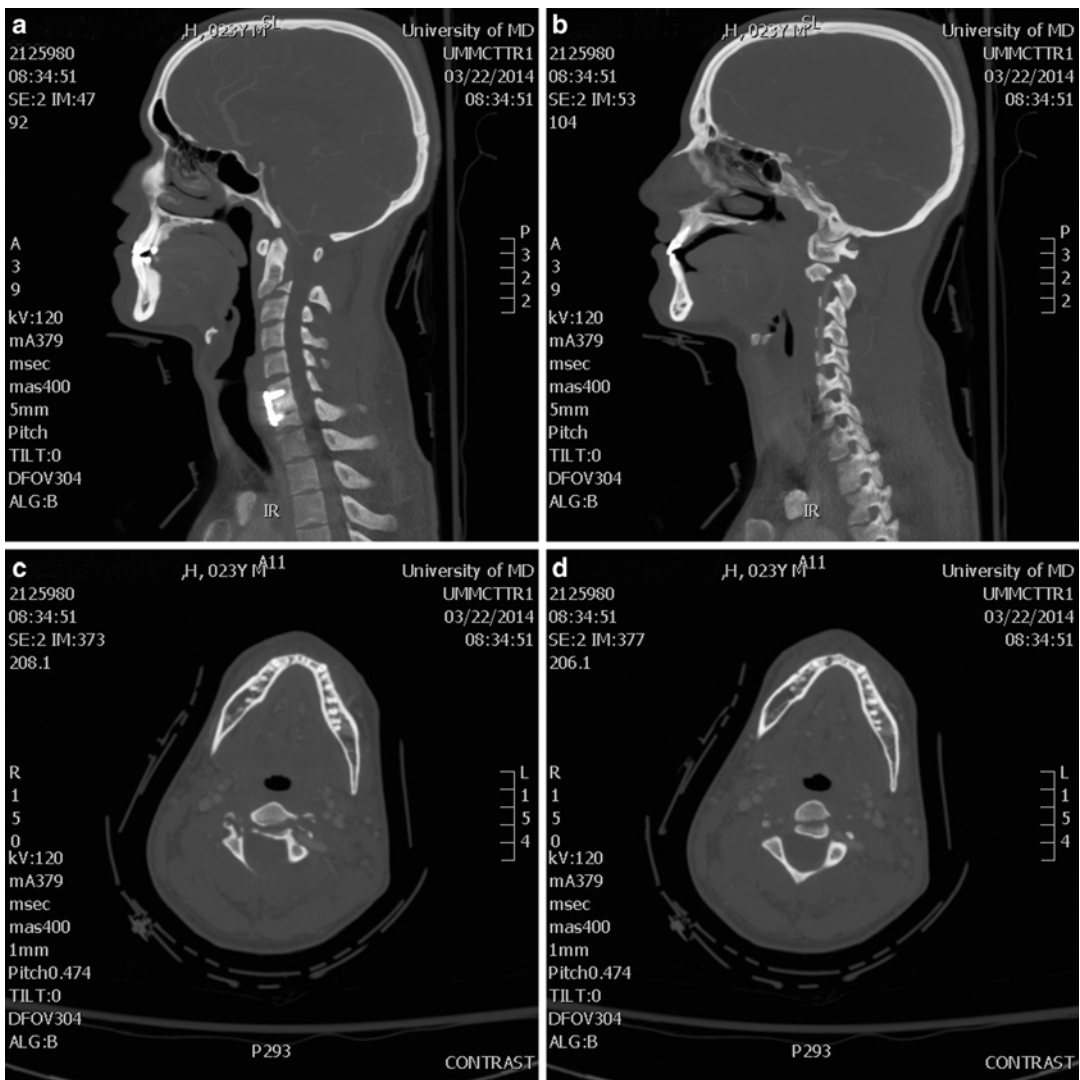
Patient was a 23-year-old man who sustained a Type II Hangman’s fracture after a motor vehicle collision. (a, b) Sagittal view CT scans. (c, d) Axial view CT scans
